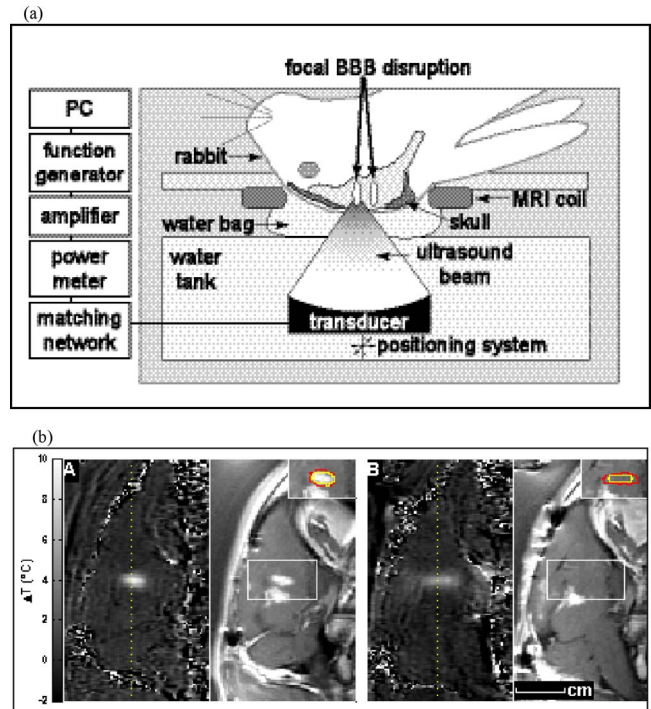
(a) Experimental apparatus used to generate the results in (b), which shows the MRI-based temperature maps (left) and contrast-enhanced T1-weighted images (right) of two sonications in two rabbit brains with (A) and without (B) preinjection of Optison®. Isotherms drawn at 3 and 4 °C are superimposed on the T1-weighted images in the insets. With Optison®, the length of the focal zone was reduced, and the heating was centered at the focal plane (dotted line in the temperature images). The images were acquired parallel to the direction of the ultrasound beam. Note that in both cases a second location inferior to the first was also sonicated. In these images, the ultrasound beam propagated in a direction from left to right. (A: 1.2 W/10 s, 2.8 MPa, pulsed; B: 3n W/10 s, 4.4 MPa, CW). From Hynynen, Ref. 185.
